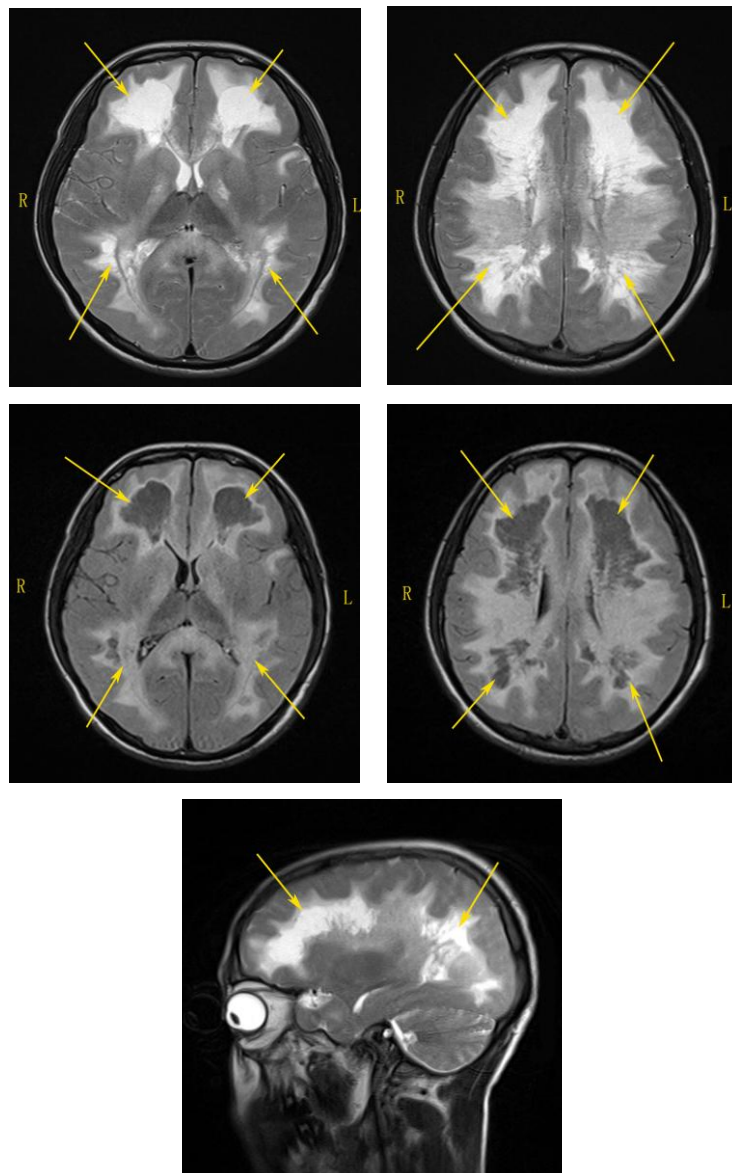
Typical brain magnetic resonance images in a patient with heroin-induced spongiform leukoencephalopathy on admission. Arrows show bilateral symmetric high-signal lesions in the white matter of the cerebrum on T1- and T2-weighted images. R: Right; L: left.
